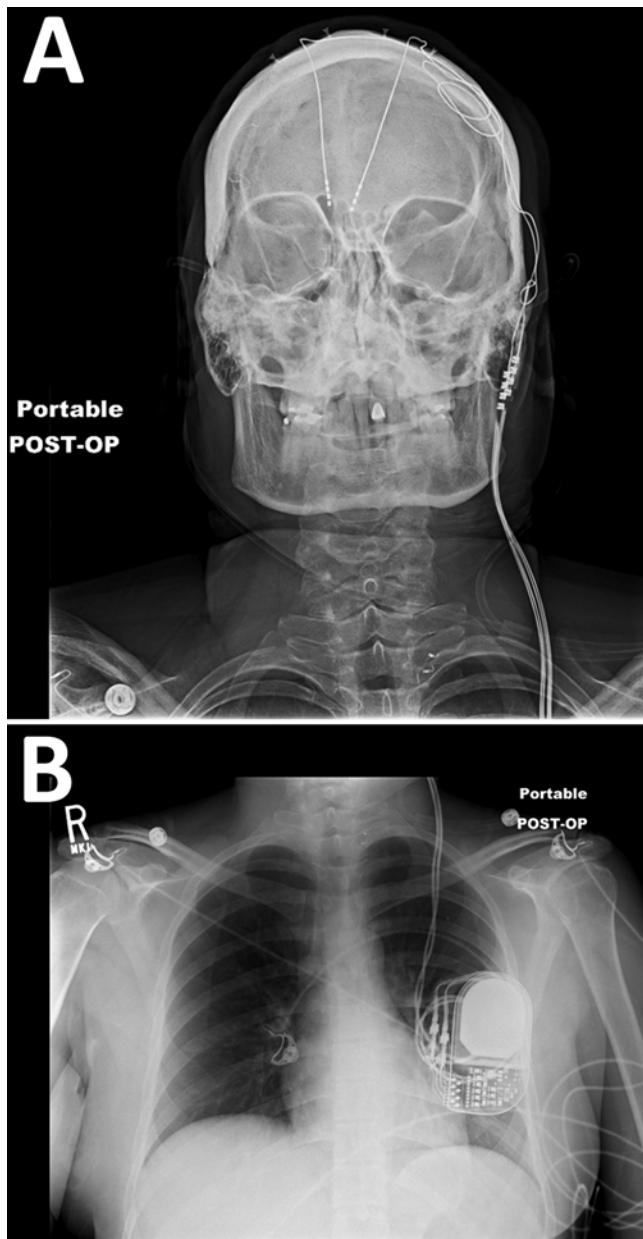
Implanted DBS for ANT. A: This anterior-posterior head radiograph shows bilateral DBS electrodes implanted within the ANT. The connectors are tunneled subcutaneously within the left neck. B: Chest radiograph showing the IPG within the left chest.
